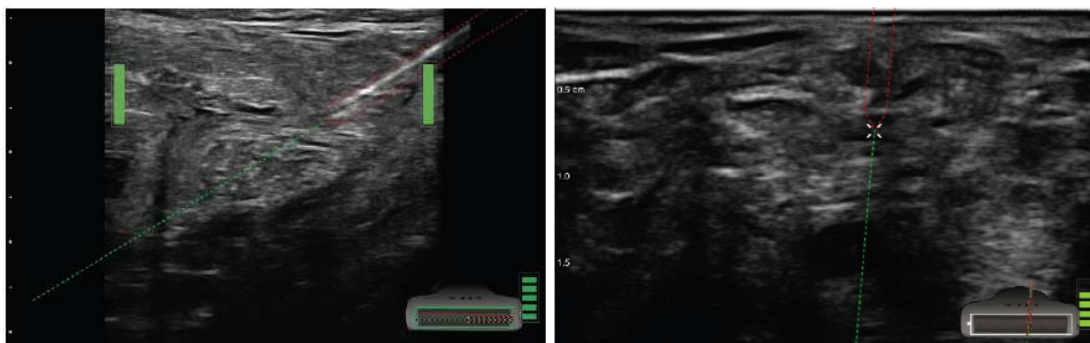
Example for the latest ultrasound-based needle guidance systems (Ultrasonix Inc) using the electromagnetic tracking system (Ascension Inc) to track the needle's motion and project it on the ultrasound image. It shows the two cases when the needle is in the image plane (left), and when the needle is out of the image plane, i.e. the needle is not in the ultrasound image (right)
